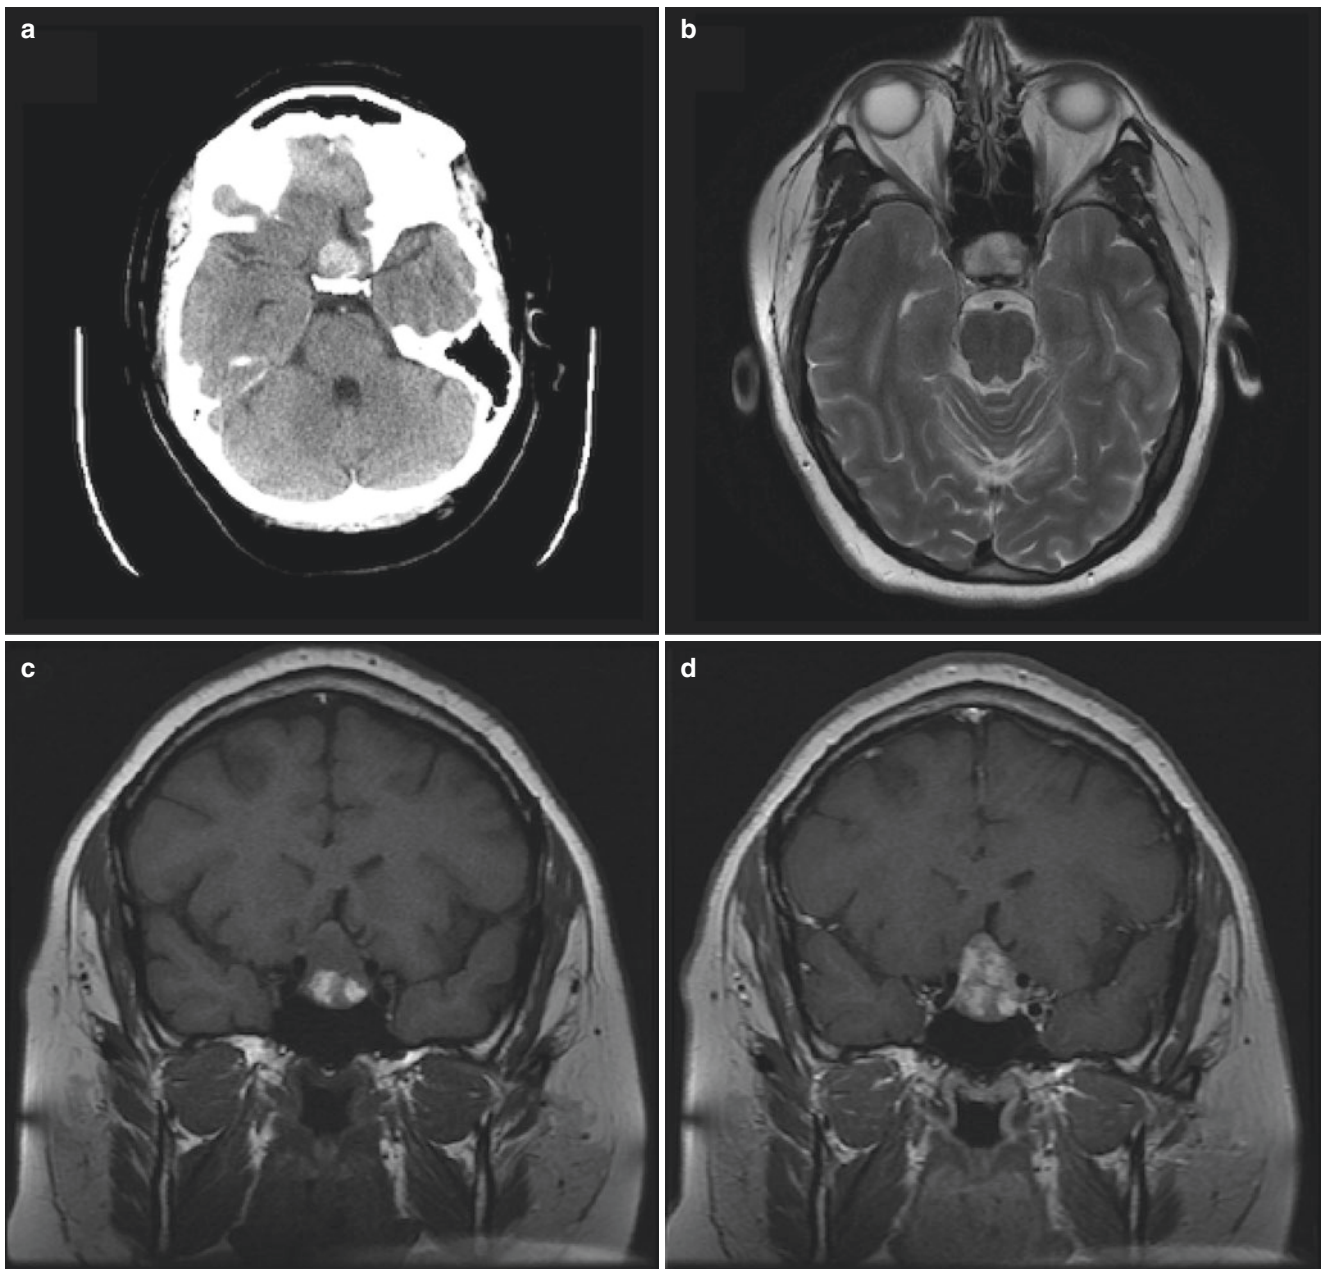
Representative images for a patient with pituitary apoplexy. Non-contrast CT axial image (a) demonstrates a hyperdense lesion in the sellar region consistent with recent hemorrhage. The T2-weighted axial MRI image (b) demonstrates an expansile hyperintense lesion in the sellar region. The T1-weighted coronal slices
